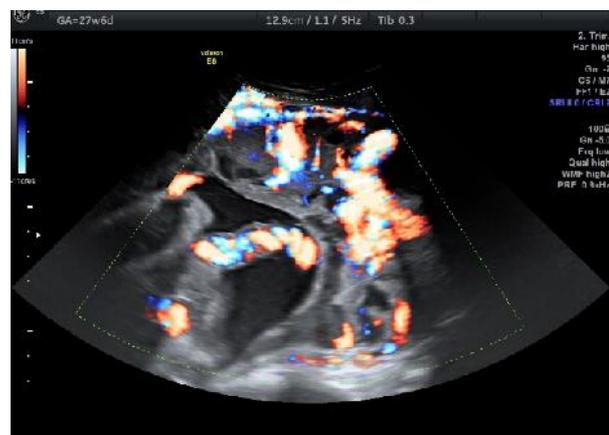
Ultrasound Doppler examination: absence of vascularization in the intravesical; solid mass.
